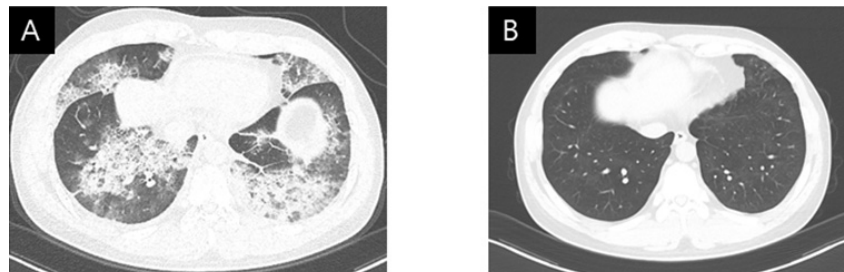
chest CT before(A) and after(B) treatment
